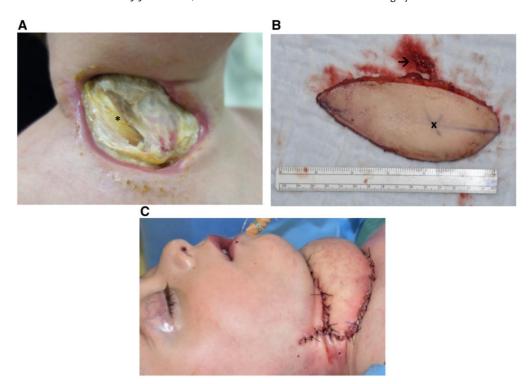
(A) Cervical necrosis affecting the sternocleidomastoideus muscle (*). (B) Raised anterolateral thigh-flap; vascular pedicle (\rightarrow) and preoperatively marked Doppler signal site (x). (C) Intra- and postoperative paleness and marbled skin depicting impaired flap perfusion.
